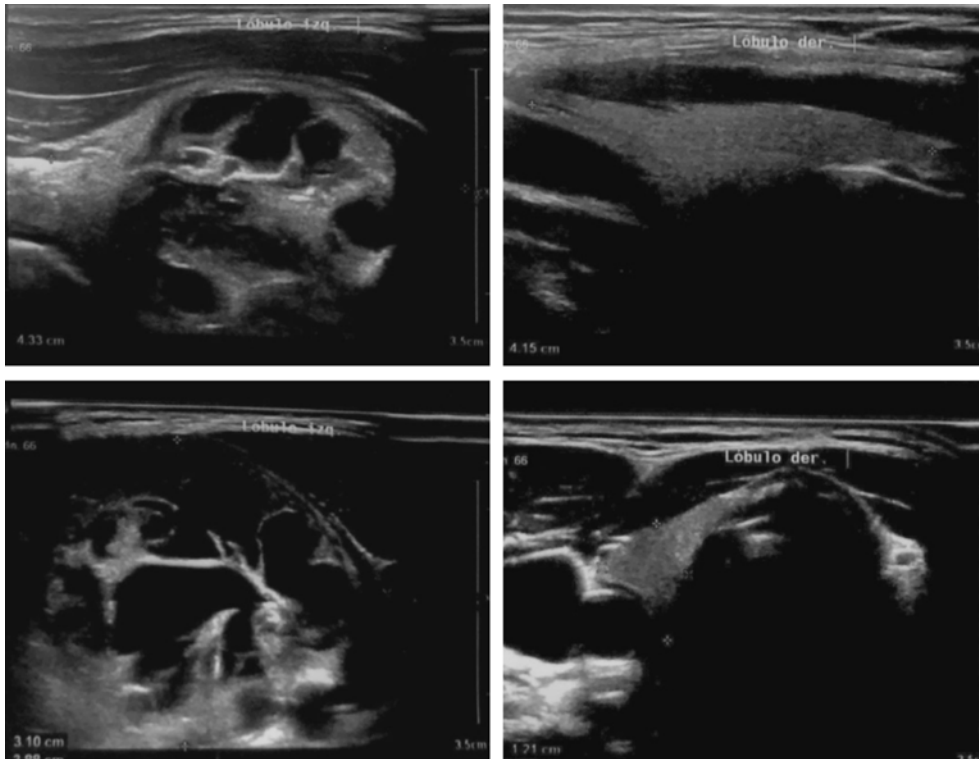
Ultrasonography showing a 45mm mixed nodule in the left lobe.
